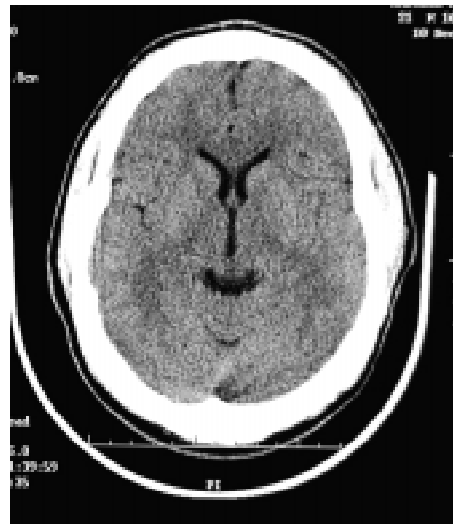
CT scanning of pt. 3.
